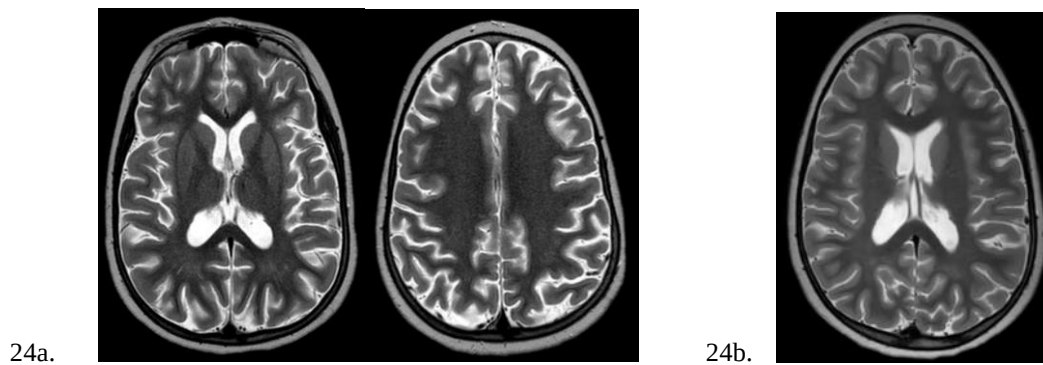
24a. 6 ys Brain MRI demonstrating cerebral and cerebellar atrophy with bilateral white matter thinning and ex vacuo ventricular enlargement. Persistent diffusion restriction of the fornix columns and subtle T2/FLAIR hyperintensity of the optic chiasm are evident. 24b. 6.2 ys. Post-treatment follow-up. Brain MRI demonstrates resolution of the prior diffusion restriction involving the fornix columns, near-complete resolution of the subtle optic chiasm T2/FLAIR hyperintensity, and overall improvement in cerebral trophism.
